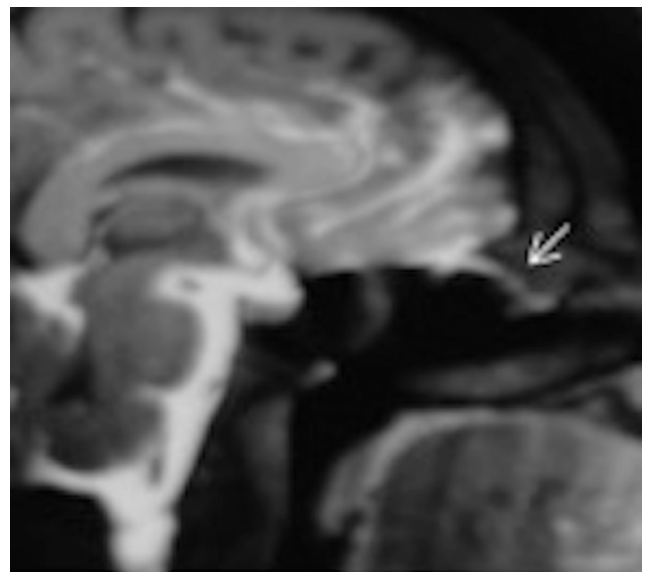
Sagittal plane magnetic resonance cisternography image of a 48-year-old man with postoperative clinical signs of a cerebrospinal fluid (CSF) fistula and positive laboratory findings. An obvious bony defect was not identified on the high-resolution coronal computed tomography (not shown). In this patient, the leakage of contrast-enhanced CSF through the cribriform plate (arrow) could only be visualized on scans repeated after 12 hours, after a Valsalva maneuver.
